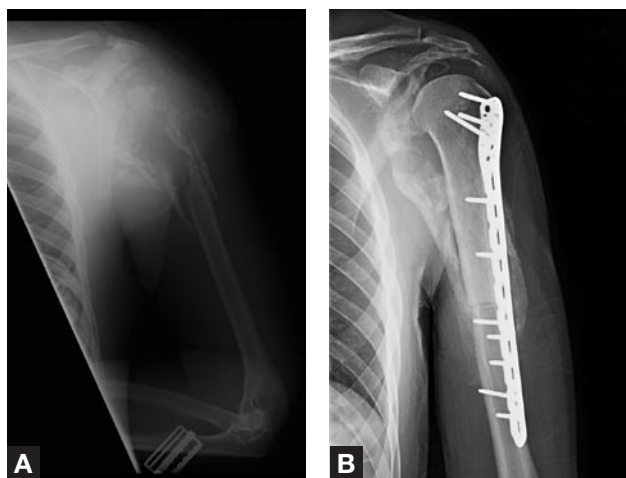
(A) Injury x-ray shows a comminuted type IIIA proximal humerus fracture. (B) X-ray 13 months after surgery shows healing of the osteoarticular proximal humeral allograft.
